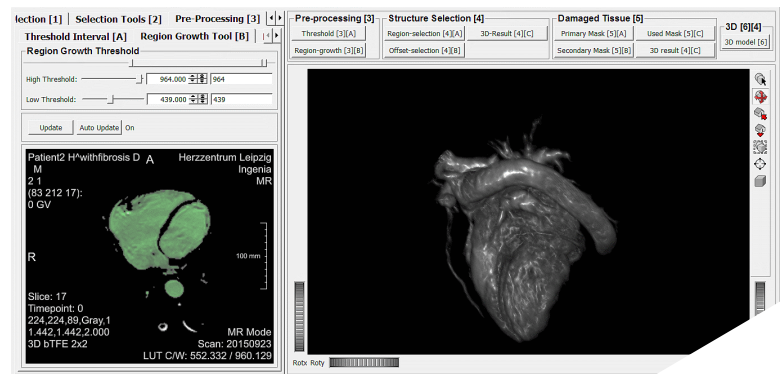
3D heart model generated based on MRI data and including the heart cavities and the vascular structures.
